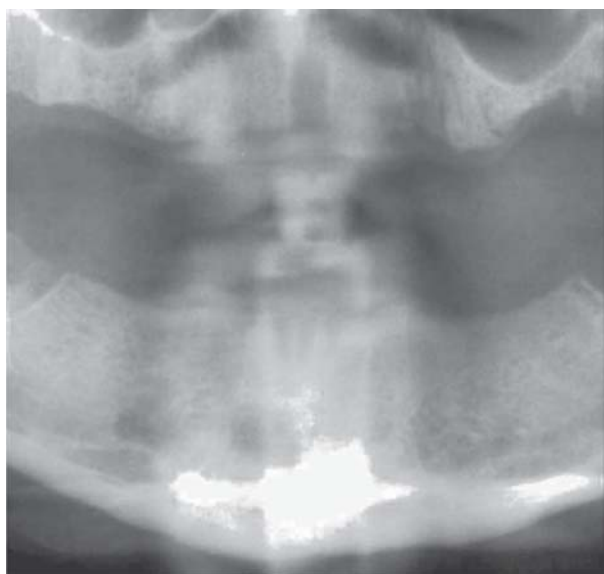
Radiograph of the lesion presenting mild osteolysis without significant bone destruction
